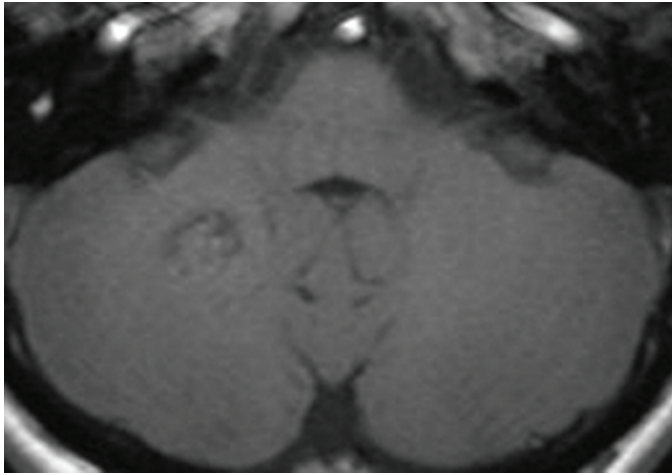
The axial unenhanced T1-weighted image shows the cavernous angioma in the right cerebellar hemisphere. There is no evidence of other abnormalities.
